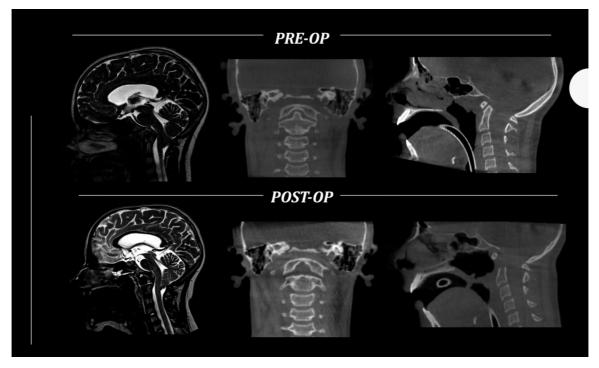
Pre- and postoperative MRI and CT images. CT, computed tomography; MRI, magnetic resonance imaging.
